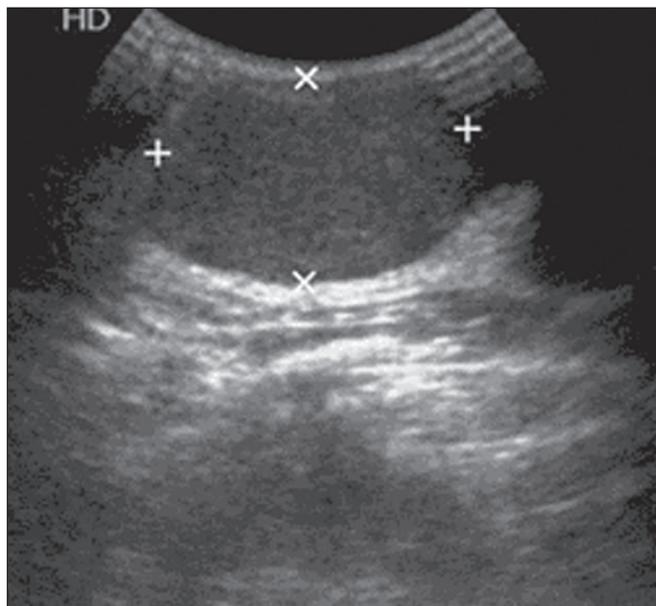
Ultrasound showing oval, circumscribed, hypoechoic nodules, with their longest axis parallel to the skin, suggestive of lesions that are probably benign in nature.
